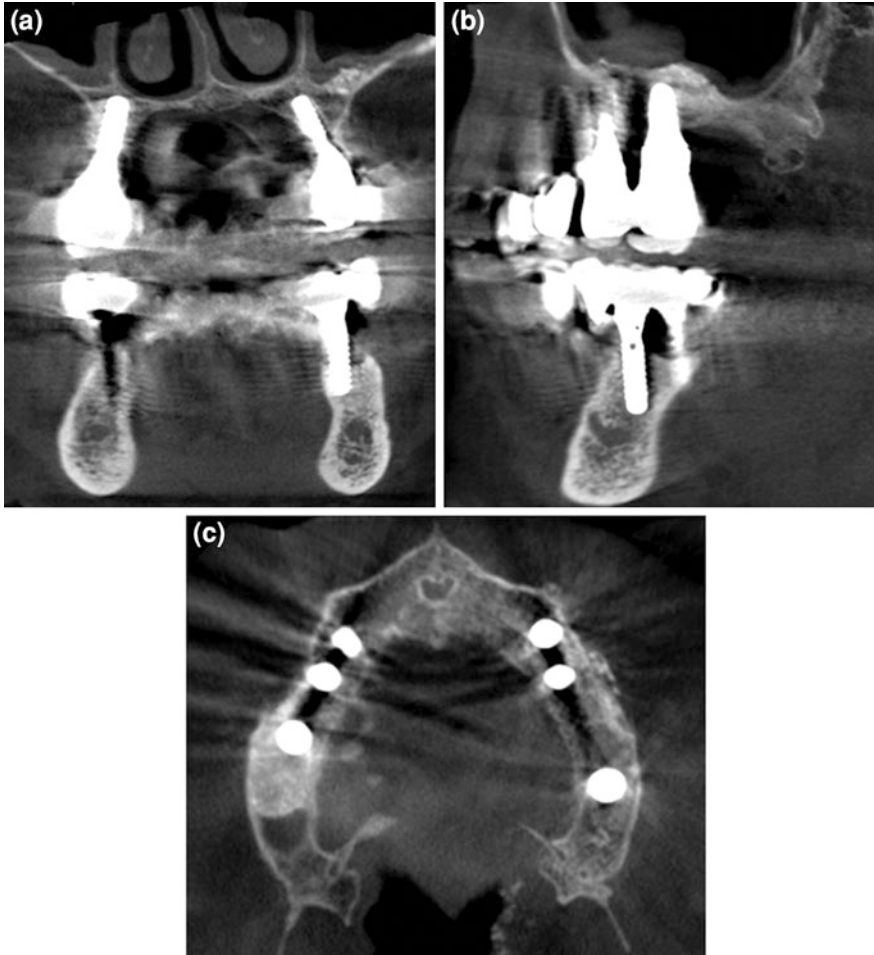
CBCT coronal (a), sagittal (b) and axial (c) sections showing the post-operative maxillary region
